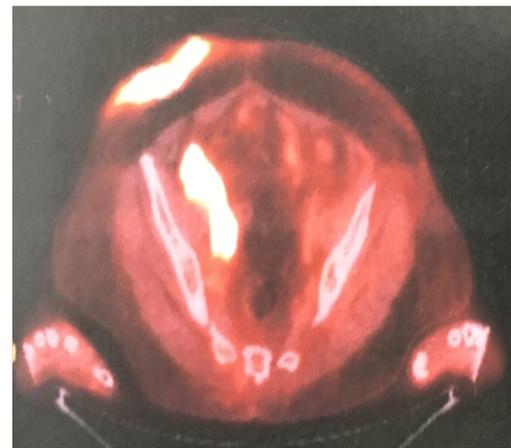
Hypermetabolic areas in the 18-FDG Pet-scan
